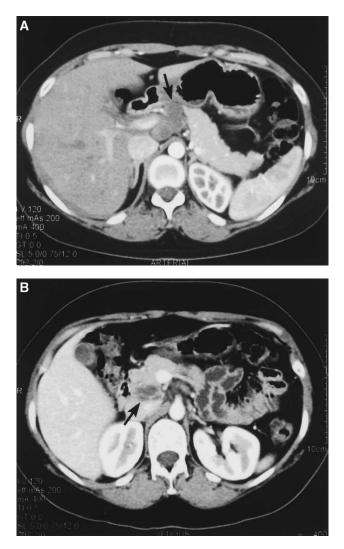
Dual-phase (A, arterial; B, venous) spiral computed tomography scan of the pancreas demonstrating a cystic lesion apparently extending into or arising from the neck or uncinate process of the pancreas. For each image, the black arrow points to the large cystic mass in the pancreatic or peripancreatic region.
